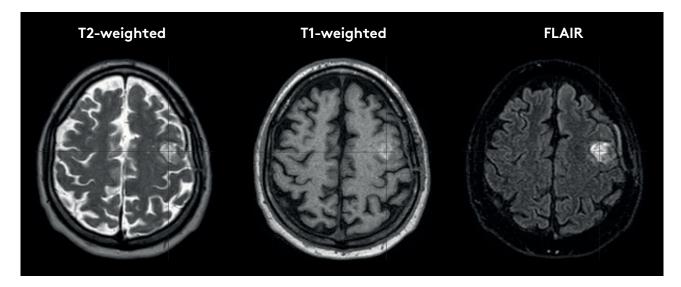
Example of a T2-weighted, T1-weighted and FLAIR MRI of the same patient acquired on Elekta Unity, which can all be acquired within 4 minutes with sub-millimeter resolution.
